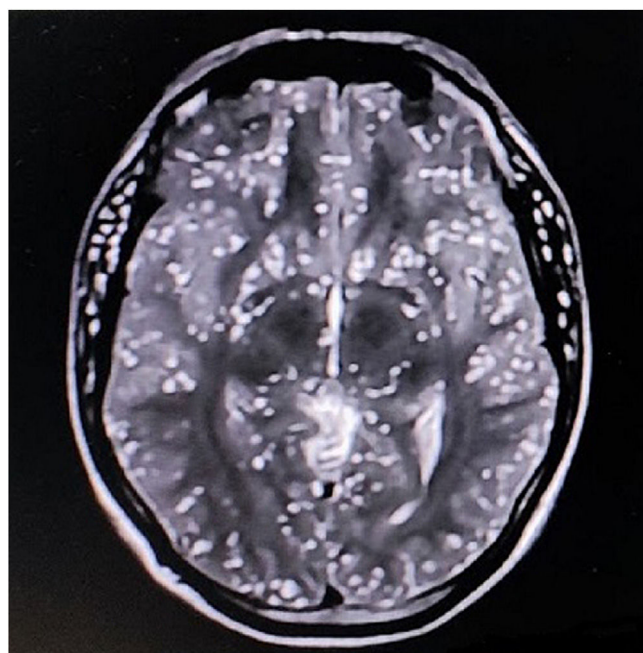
Brain magnetic resonance imaging reveals the starry sky appearance of neurocysticercosis on axial-T2-weighted imaging (A).
